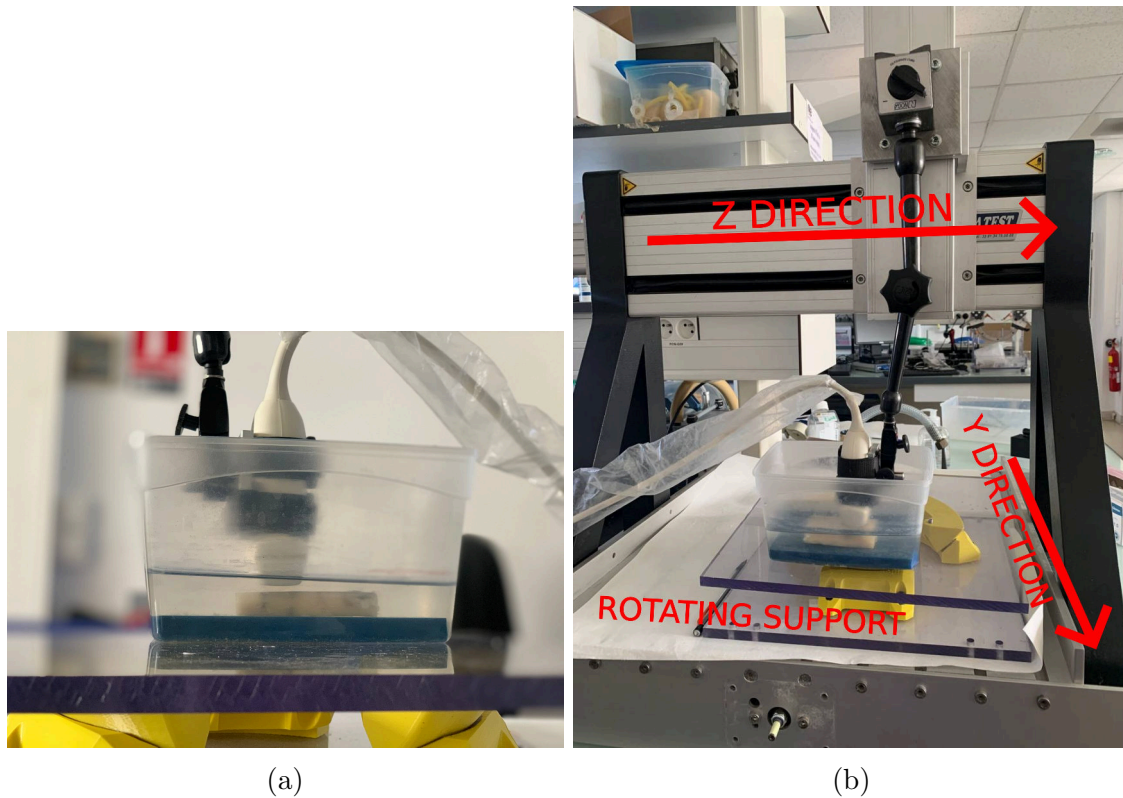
Experimental setup for ultrasound acquisitions, with the probe positioned in front of the sample, slightly submerged in water (panel (a)). Acquisitions were repeated 10 times with repositioning for each measurement site using the rotating support and the translating device in panel (b).
